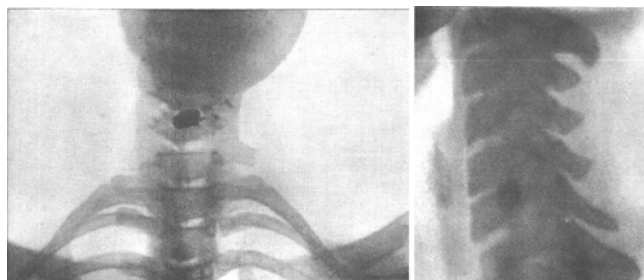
Radiographic images obtained by Cushing with the new x-ray imager. (Reproduced from Cushing H: Haematomyelia from gunshot wounds of the spine. A report of two cases, with recovery following symptoms of hemileSION of the cord. Am J Med Sci 115:654–683, 1898.)
